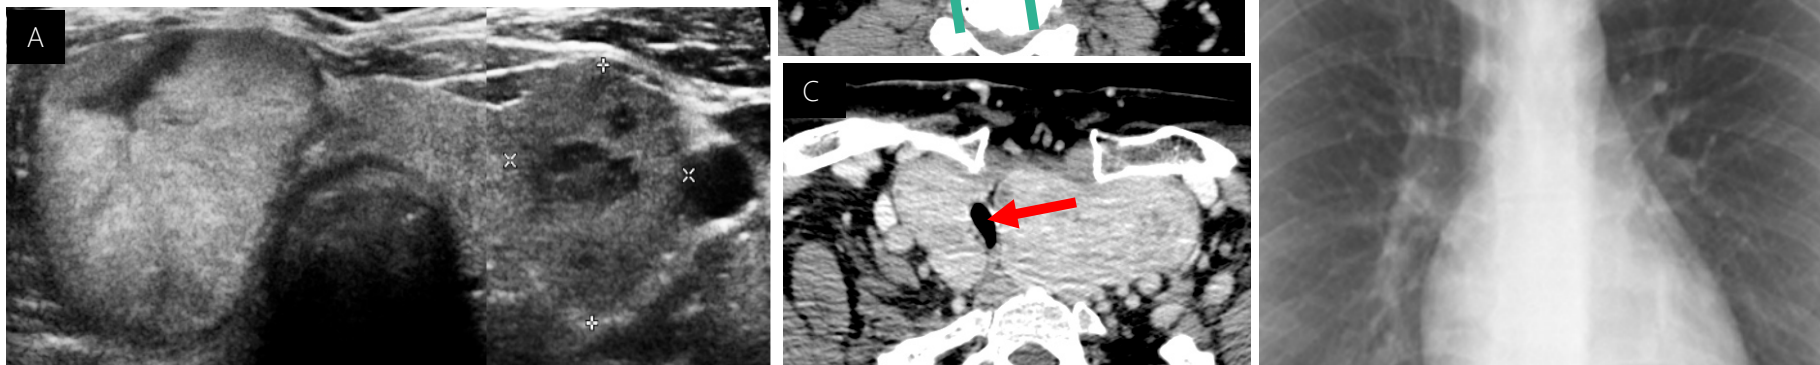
Different patients with MNG. A. Transverse US image showing an enlarged thyroid gland with bilateral nodules. B and C. Contrast-enhanced CT showing a MNG with retropharyngeal spread (green arrows) and massive tracheal compression (red arrow). D. Deviation of the trachea (arrow) and positive cervico-thoracic sign, i.e., indistinct borders above the clavicles in a patient with MNG.
